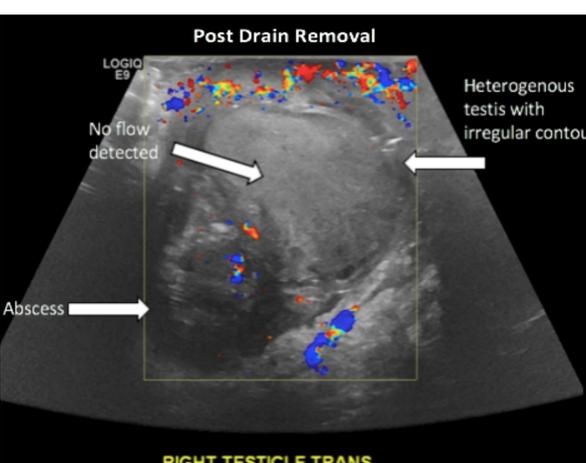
The right testicle appeared heterogenous with an irregular border. There is no vascular activity demonstrated on colour Doppler assessment indicating tissue necrosis (Chia *et al.* 2016).
